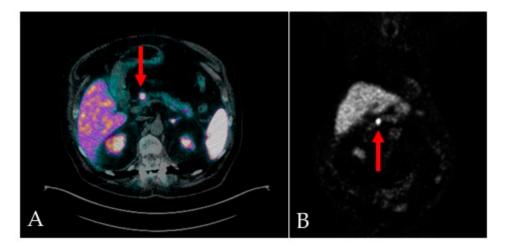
⁶⁸Ga-DOTA-TOC integrated PET/CT, transaxial (A) and MIP (B), shows focal and intense uptake in the primary pancreatic lesion (red arrows), with elevated expression of SSTR2/5 somatostatin receptors.
